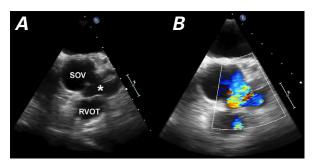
Transesophageal echocardiograms. A) The 2-dimensional midesophageal short-axis view of the sinus of Valsalva shows the pseudoaneurysm (asterisk). B) Color-Doppler mode shows turbulent flow through the narrowed neck of the pseudoaneurysm (asterisk) that communicates with the aorta.
